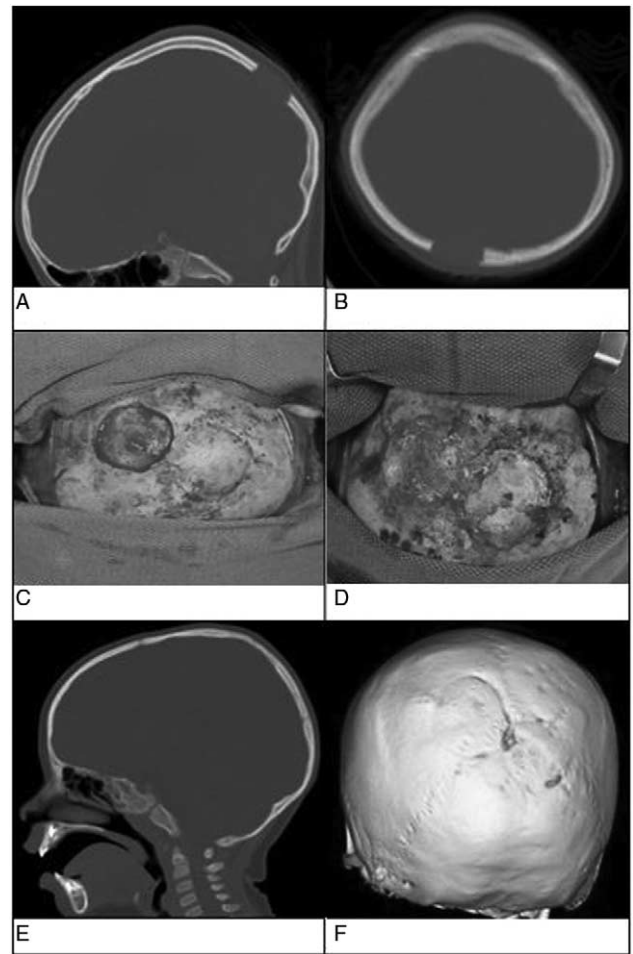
A parietal lesion with full-thickness destruction of the bone ([A] sagittal preop view, [B] axial preop view). 5-cm defect created by resection of a single parietal cranial lesions (C) and reconstruction using a split autologous cranioplasty from adjacent bone, secured with absorbable hardware (D). Postoperative computed tomography after reconstruction ([E] sagittal view, [F] 3D reconstruction).
